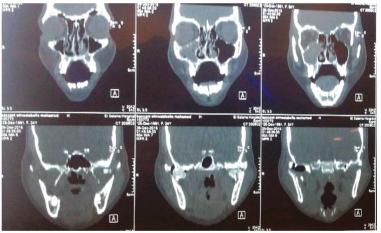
Pre-operative coronal CT cut.
